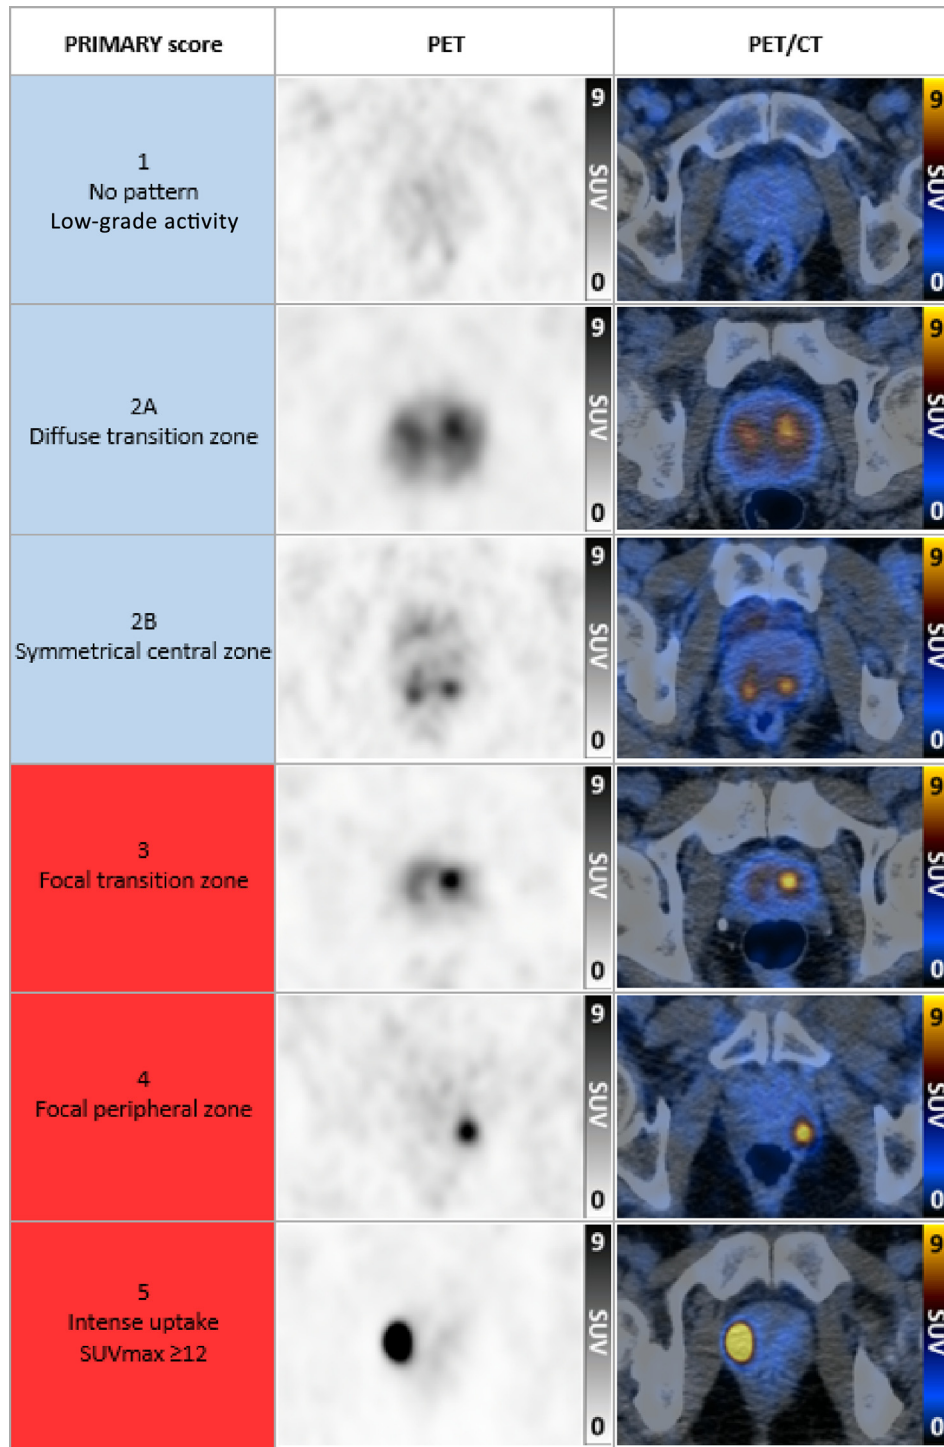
The PRIMARY scores range from 1 to 5 for intraprostatic characterisation, which is based on a combination of site (peripheral or transition zone), pattern (focal or diffuse), and intensity (SUV_{max} >12) to determine the chance of clinically significant malignancy. PRIMARY scores 1–2 are considered “benign” and 3–5 “malignant”. CT = computed tomography; PET = positron emission tomography; SUV = standardised uptake value; SUV_{max} = maximum SUV.
